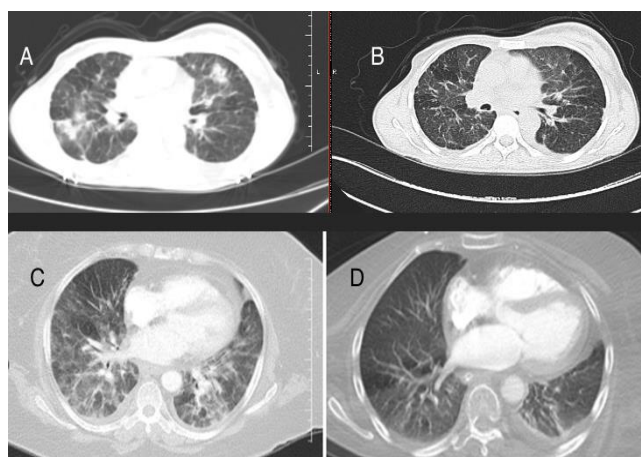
Diagnostic and follow-up thoracic CT slices of cases 7 and 8. (A) Case 7 Thoracic CT at diagnosis, (B) Case 7 Thoracic CT one month after treatment, (C) Case 8 Thoracic CT at diagnosis, (D) Case 8 Thoracic CT one year after treatment.
